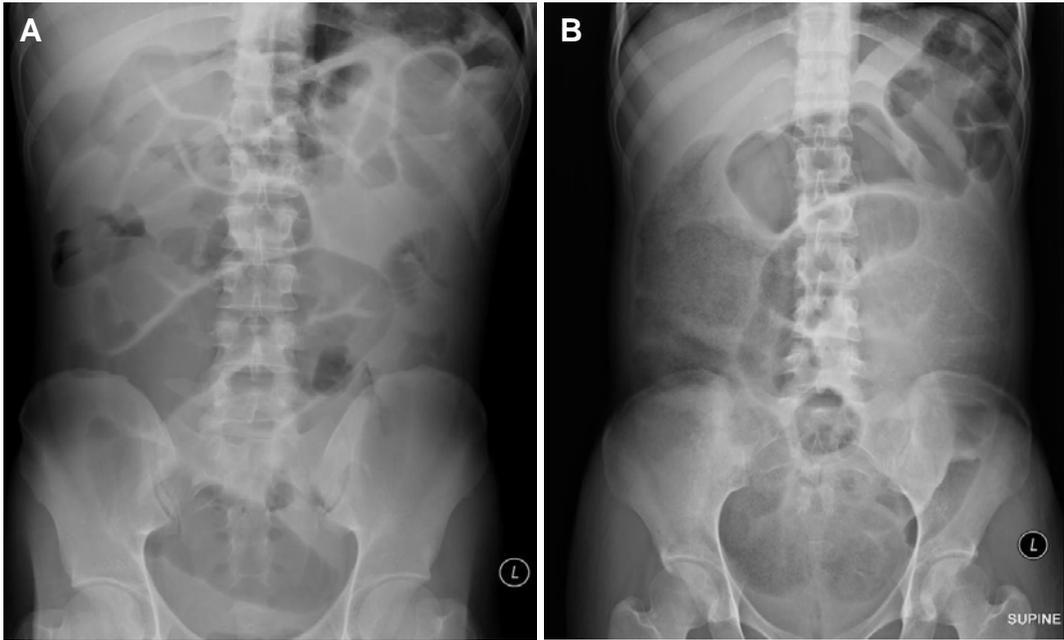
Plain abdominal radiograph. A, dilated large and small bowel in Case 1. B, Case 2 shows similar findings as in Case 1.
